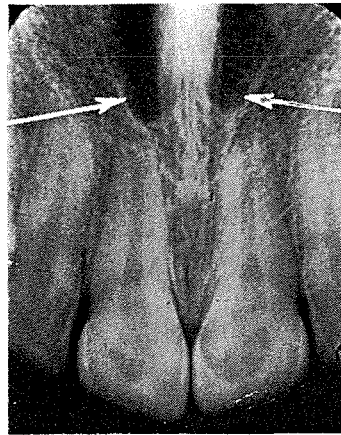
Periapical radiograph showing nasal fossa
